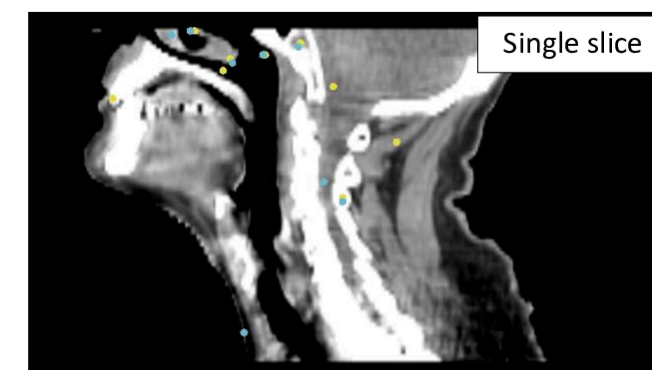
Visual display of the characteristic matching points identified on the CBCT (yellow) and sCT (blue) in the sagittal view with the SIFT algorithm. Both sets are overlaid on the CBCT.
